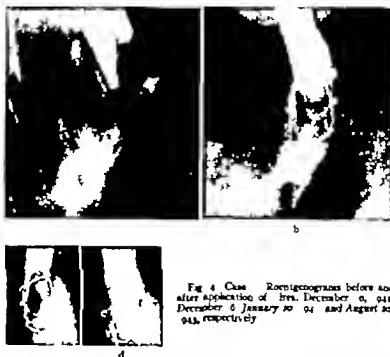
Case. Roentgenograms before and after application of Irs. December 6, 1941, December 6 January 20, '42 and August 20, 1942, respectively.
